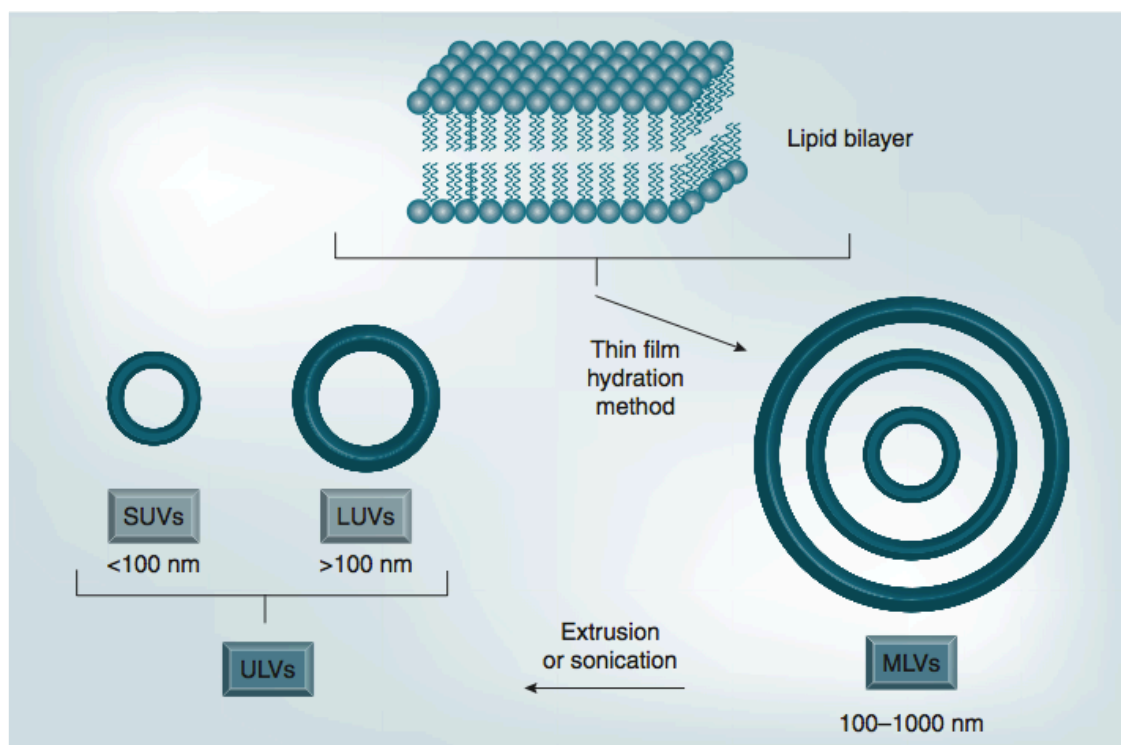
Liposomes classification regarding their size and number of lipid bilayers. MLVs: Multilamellar vesicles; ULVs: Unilamellar vesicles; SUVs: Small lamellar vesicles; LUVs: Large lamellar vesicles. Data collected form [30].
